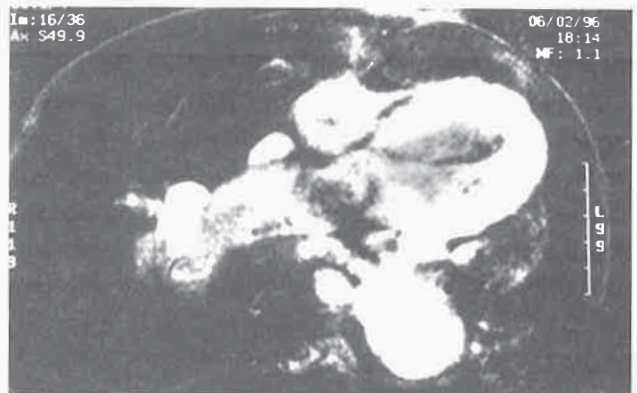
Magnetic resonance imaging of the aneurysmal dilatation of the pulmonary trunk
